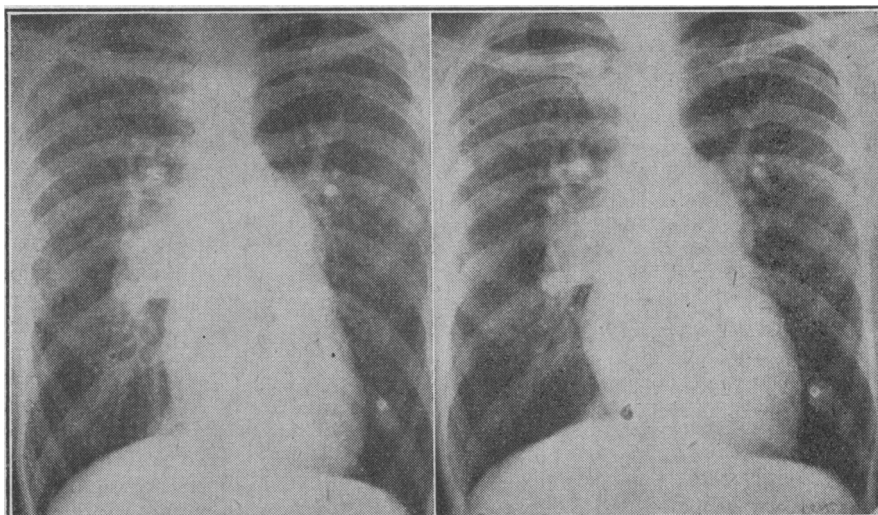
Teleradiographs of a man of 26 (G6) six months before and 19 months after operation. Nine years' history of increasing breathlessness and severe pulmonary congestion; he could walk only 20 yards (18 metres) without symptoms; tight mitral stenosis and marked pulmonary hypertension (mean pulmonary artery pressure 100); radiograph shows haemosiderosis. Since operation, on March 2, 1950, has led a full working life; post-operative pulmonary artery pressure, 55.
